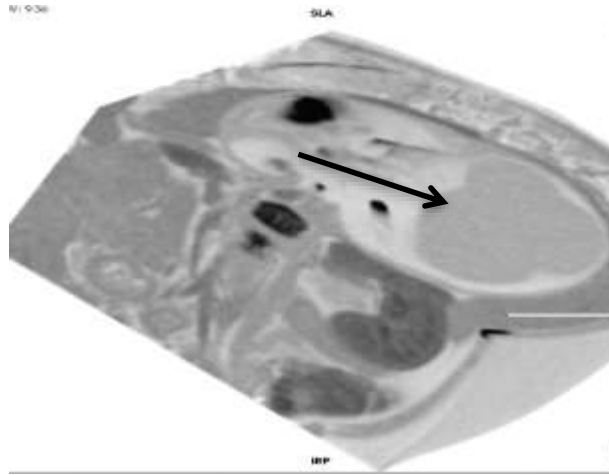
3D volume rendering technique show the lobulated cystic lesion (black arrow) at right upper abdomen/ suprarenal region as previously depicted in ultrasound.
